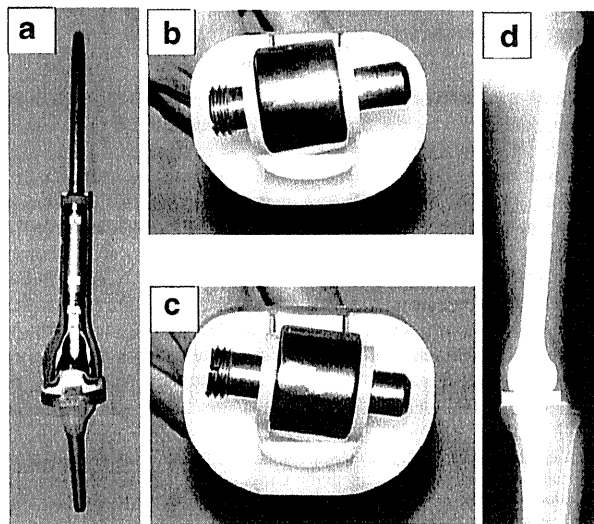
The photographs showing (a) an overview of the PHK III and a unique semi-rotating hinge joint (b and c) which allows internal/external-rotation of 5°. (d): Radiography showing anterior-posterior view of PHK III used for the osteosarcoma patient.
